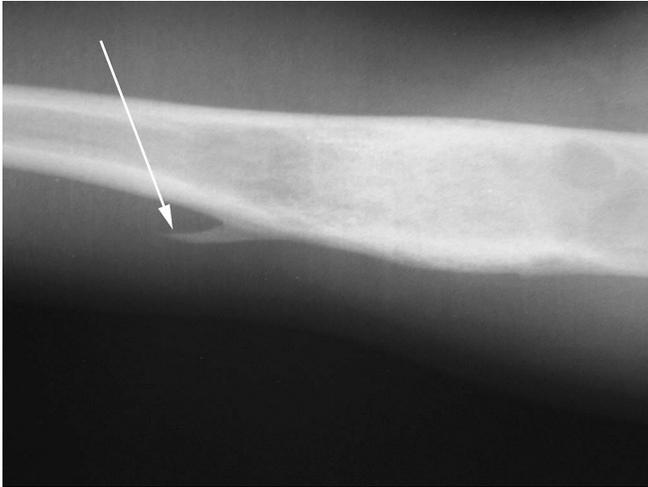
Radiographic aberration at the working entry point to the cyst, resembling an exostosis (arrow). All patients were asymptomatic. This finding can be attributed to spillage from excessive mixture that leaked after the trocar was withdrawn.
